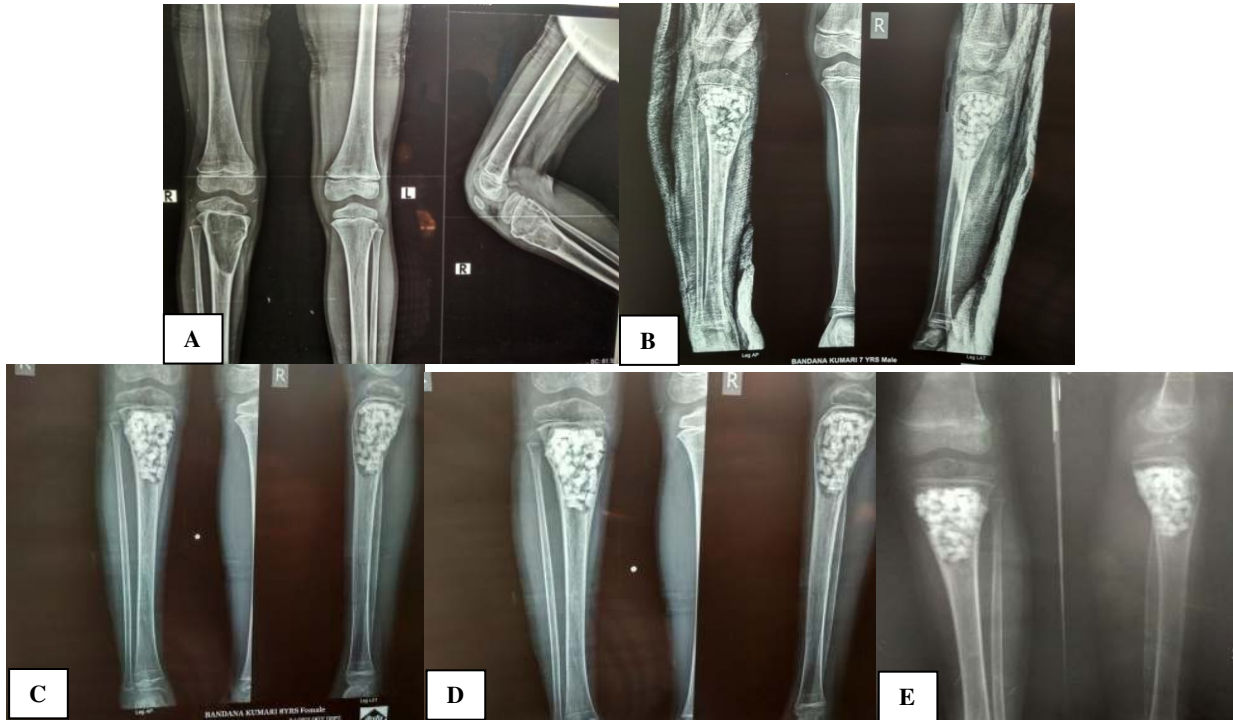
(A) Aneurysmal bone cyst with impending fracture in right proximal tibia in 8 year old girl; (B) post-op X-ray of curettage and bone grafting; (C) at 2 months follow up; (D) at 6 months follow up; (E) follow up at 12 months showing partial incorporation of graft (Irwin grade II).
